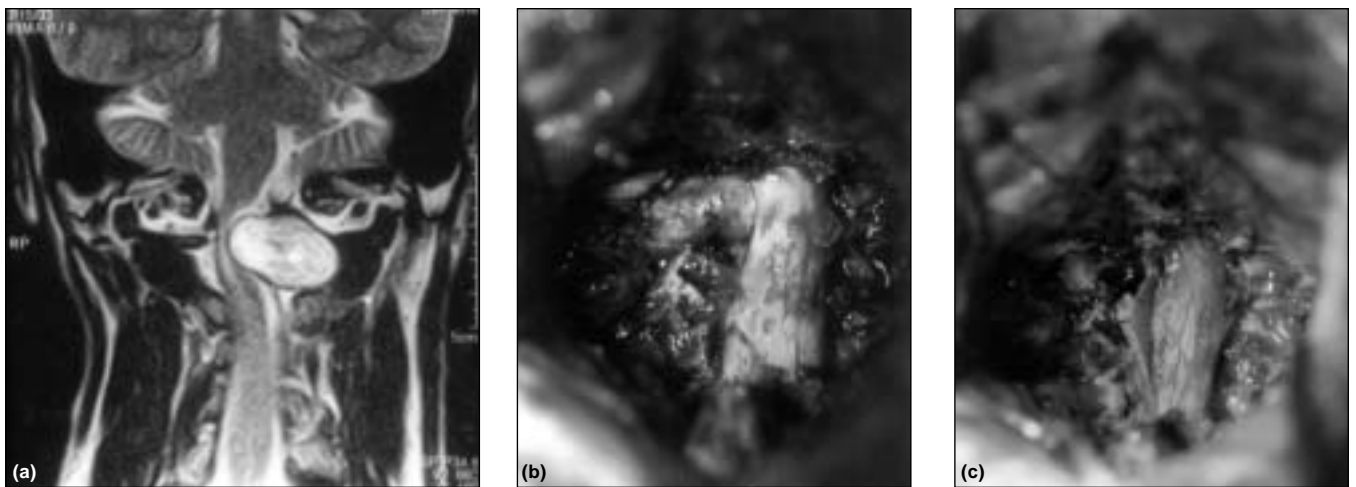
(a) Preoperative T2-weighted coronal MR image showing a dumb-bell nerve sheath tumor with a large extraspinal component; (b) Intraoperative photograph of the C2 neurinoma exiting through the intervertebral 'foramina'; and, (c) Intraoperative photograph showing total excision of the intra- and extradural component of the tumor.
